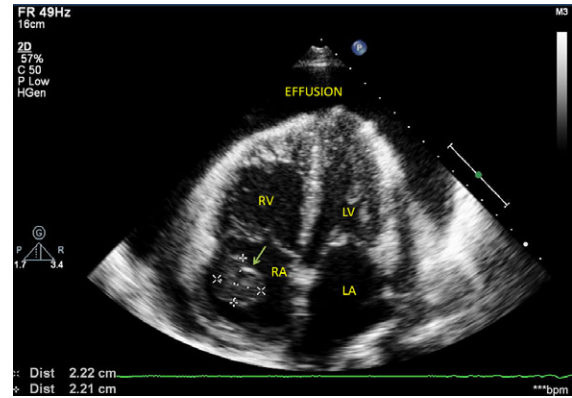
Apical four-chamber view showing the right ventricle (RV), left ventricle (LV), left atrium (LA), and right atrium (RA). There is a well-defined rounded mass (thrombus) in the RA (arrow).
